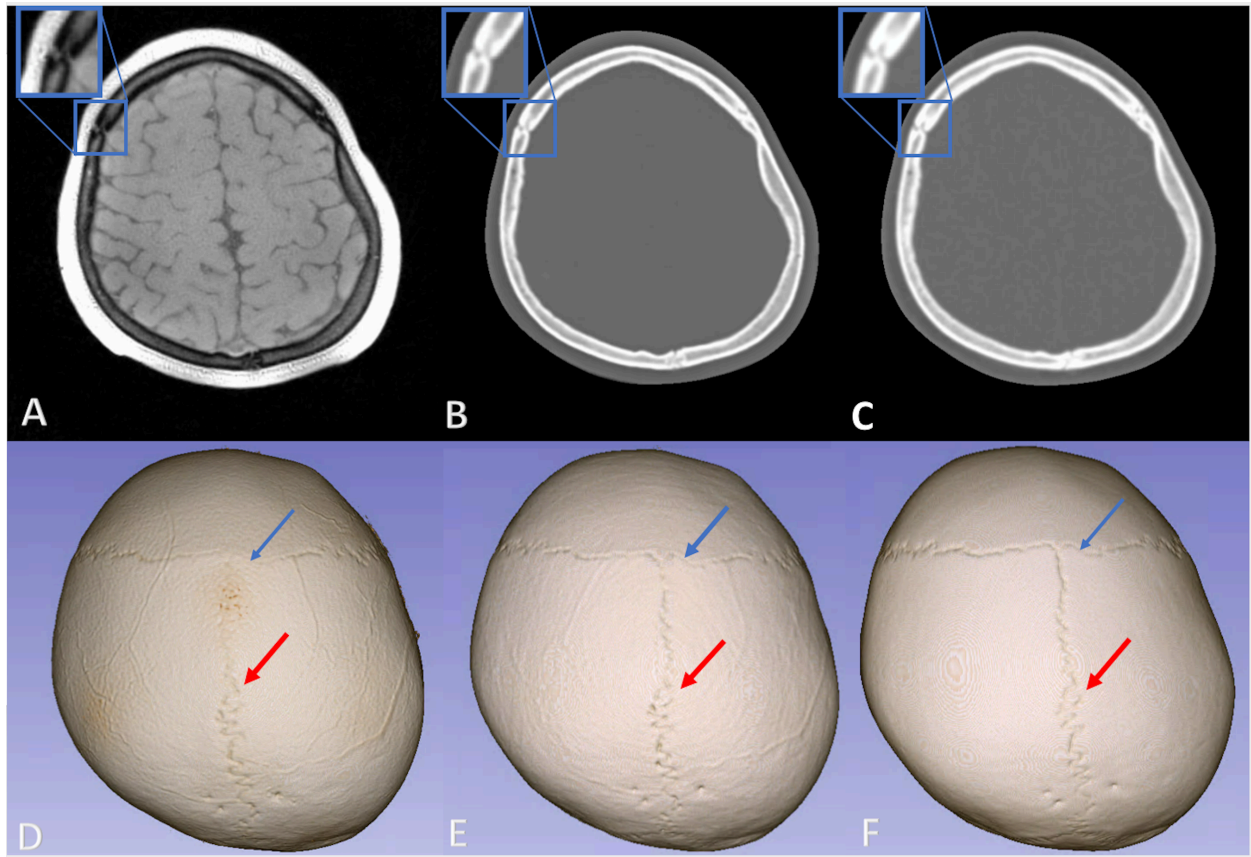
Representative volumetric MR (A), pCT<sub>Com</sub> (B), and CT (C) images from a patient (14-year-old, female) with a suture marked in the blue square, and the corresponding 3D surface rendered cranial bone images of manual inverted MR images (iMR) (D), pCT<sub>Com</sub> (E), and CT (F). The blue and red arrows indicate the presence of the coronal and the sagittal sutures, respectively.
